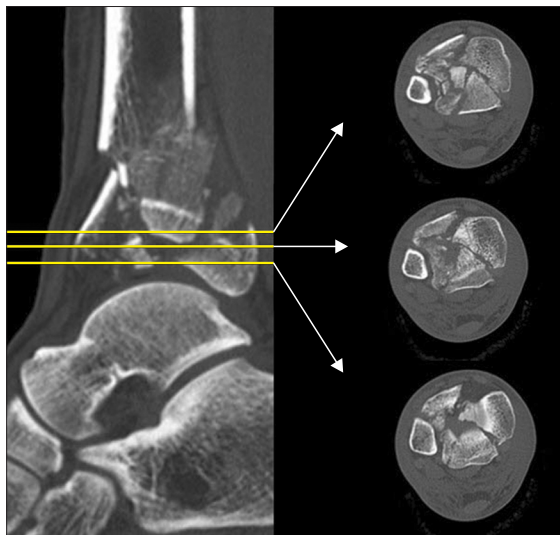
It is difficult to determine the articular surface if there is an impacted fragment (die-punch fragment). Even a little change in the level of the articular surface results in a difference in the computed tomography axial cut image.
